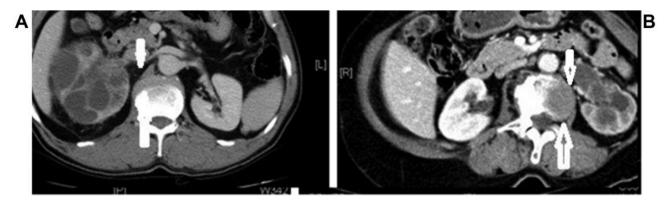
Computed tomographic scan showing direct L2 vertebral body invasion from renal pelvis carcinoma. Representative axial views of right (A) and left (B) renal pelvis malignancy showing tumors with direct L2 vertebral body invasion (arrows).
